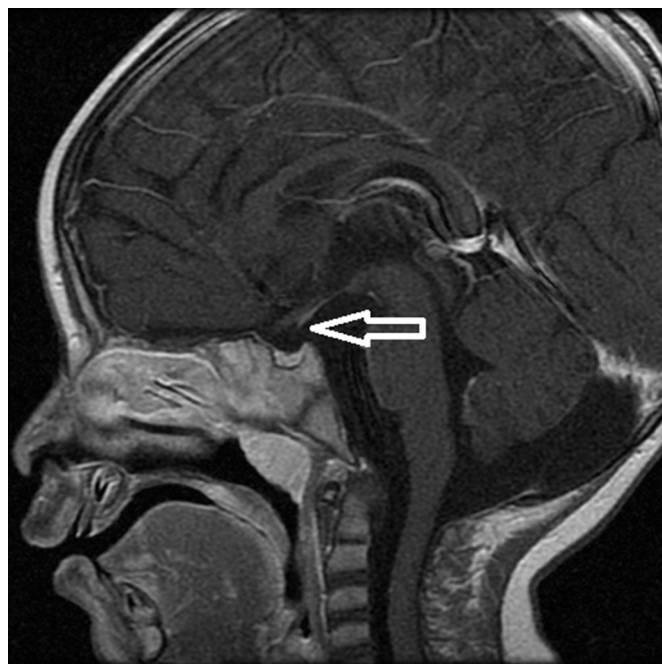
Contrast enhanced T1-weighted sagittal image.
